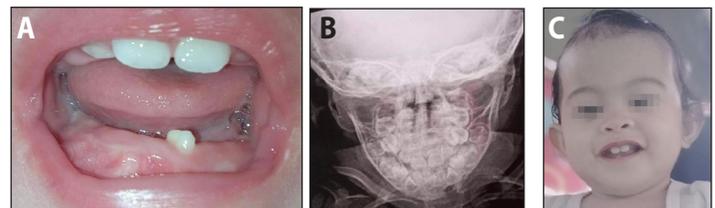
One year follow up showing A. tooth eruption; B. radiograph with good bone deposition and tooth buds; and C. patient thriving with successful union of the mandible and no facial asymmetry.
